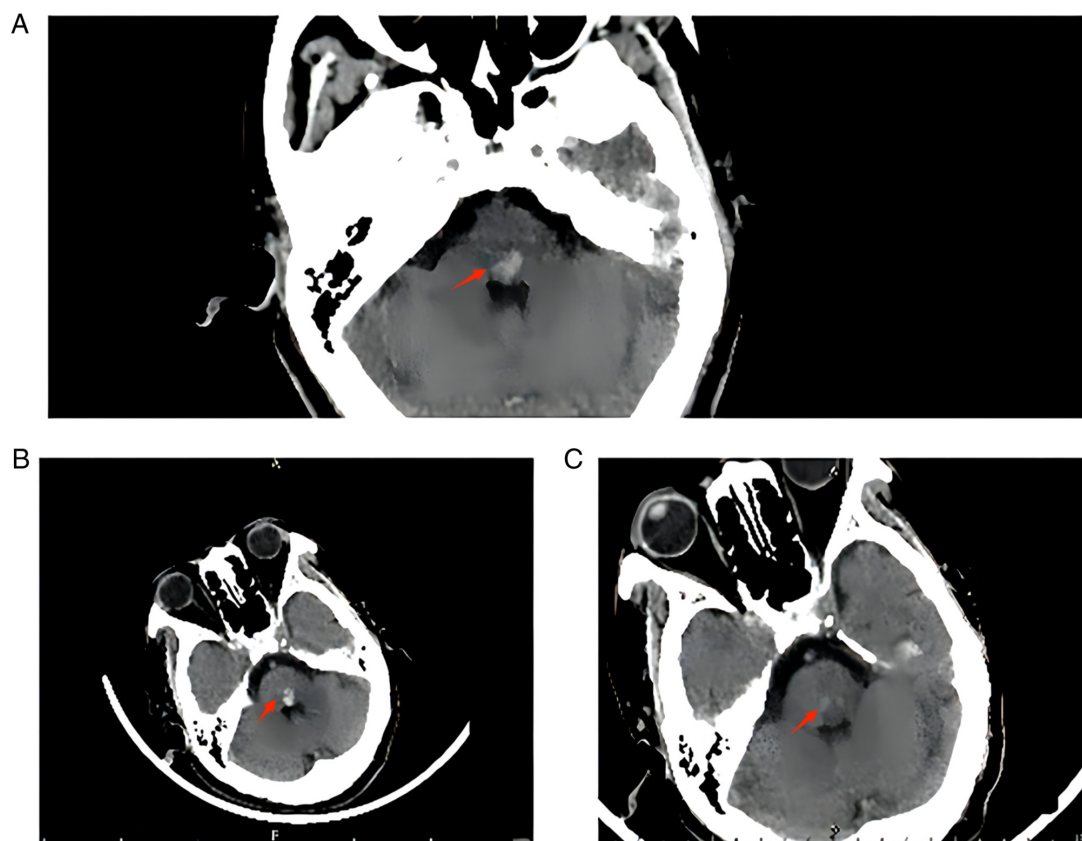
(A) Brain CT on 14th May 2022 showed patchy high density in the brainstem with clear borders, which was considered to be a haemorrhage. (B) Brain CT on 17th May showed patchy high density in the brainstem with clear borders, which was considered to be a haemorrhage slightly increased compared with that of 14th May. (C) Brain CT on 27th May showed patchy high density in the brainstem with clear borders, which indicated that the haemorrhage appeared to be decreasing in extent and had a reduced density compared with that of 17th May. The red arrow shows the haemorrhage site. CT, computed tomography.
